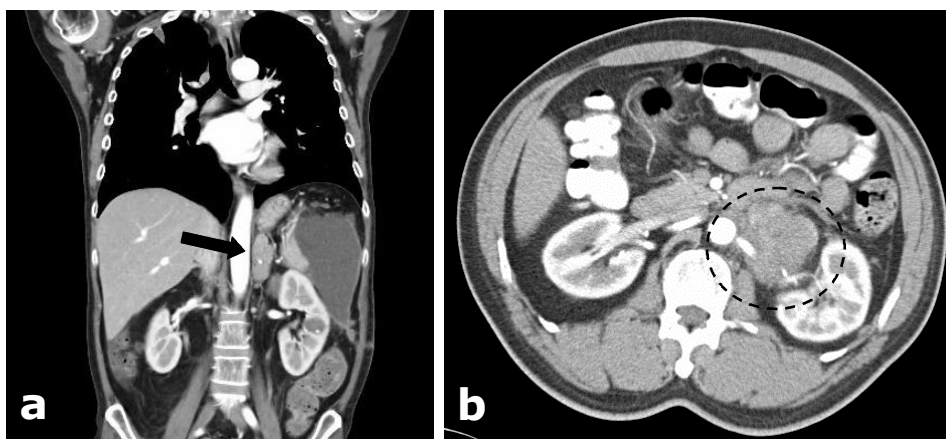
a) Coronal post-contrast CT showing a left heterogenous enhancing adrenal mass (6 x 7cm, arrow) (Case 1), b) a contrast image showing an enhancing heterogeneous mass (5.5 x 5.9 x 6.6cm, broken circle) seen arising from the left adrenal gland, encasing the left renal artery and vein (Case 4).
